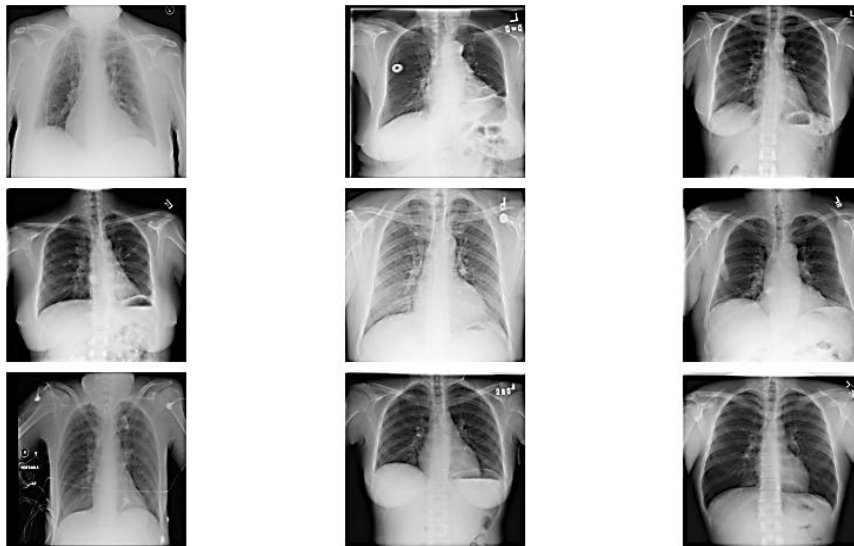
Sample Chest X-ray Images for Respiratory Disease Detection
